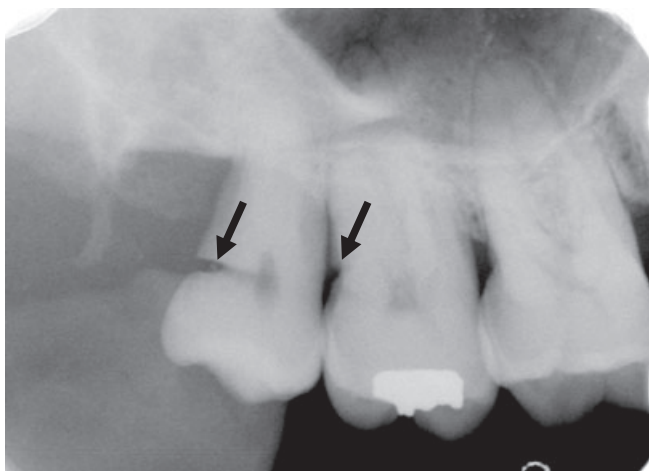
Radiograph of maxillary left molars. Note deep notch-like lesion at the distal cementoenamel junction of tooth no. 1 and a similar but more shallow lesion on the distal root surface of no. 2 (arrows).
